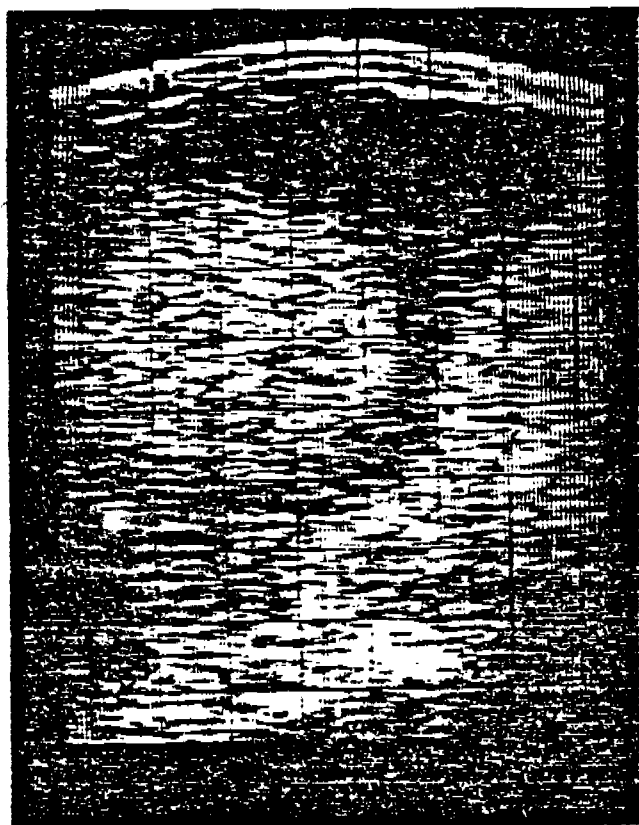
Sonographic longitudinal section through the liver at the level of the right mid-clavicular line. Solid tumor of around 10cm in diameter.
